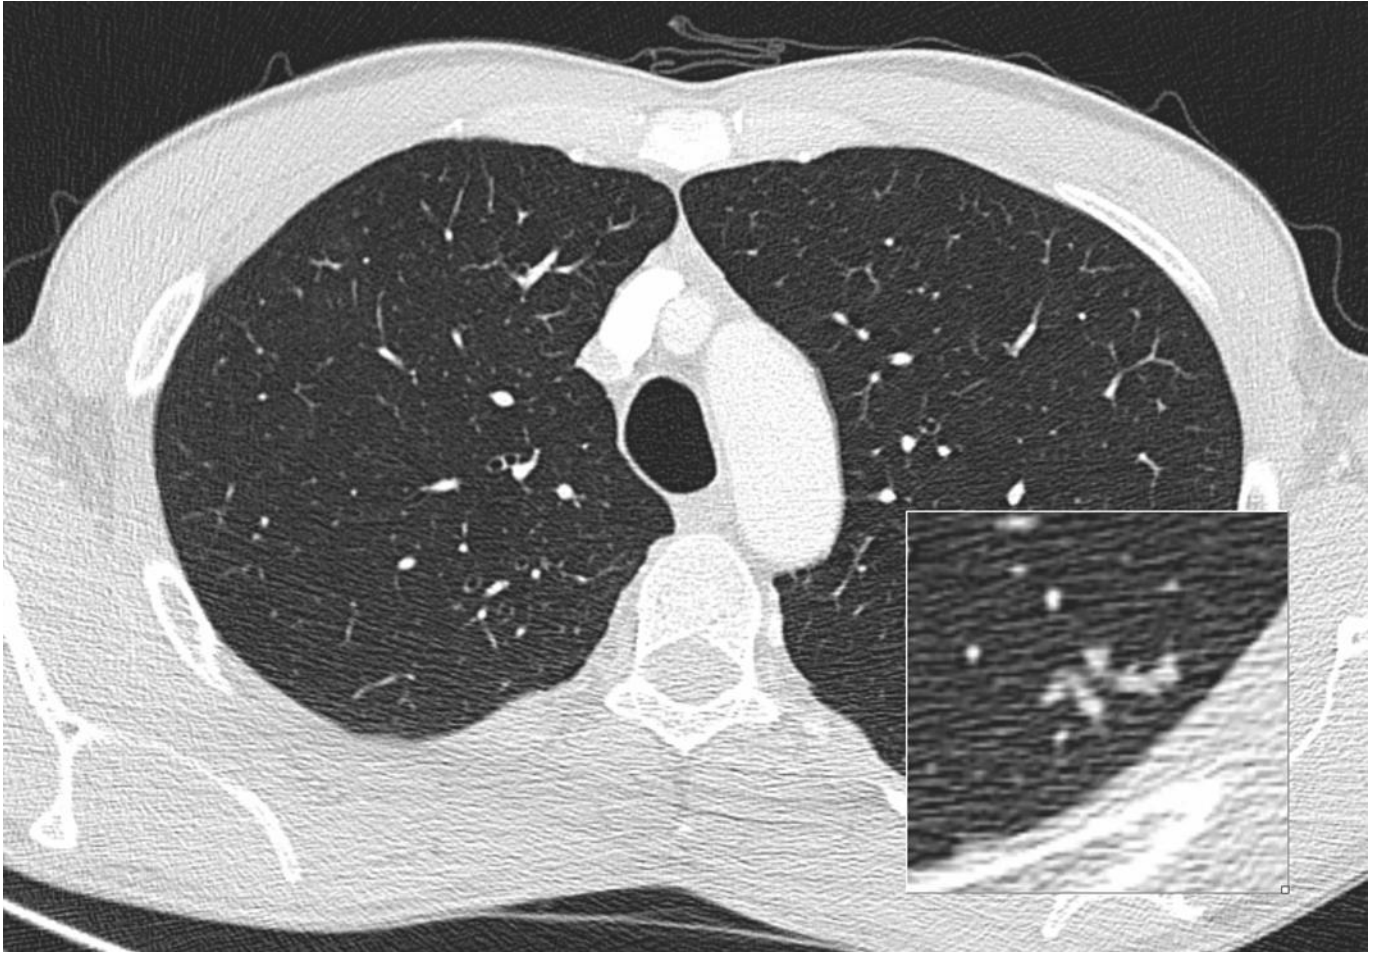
Chest CT of male contact at week 12 of the patient's treatment. The highlighted area in the left lower zone is magnified.
